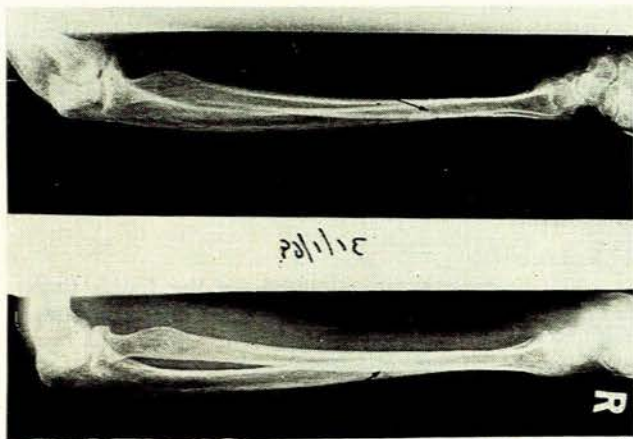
X-ray of forearms. Note symmetrical nature of fractures.
